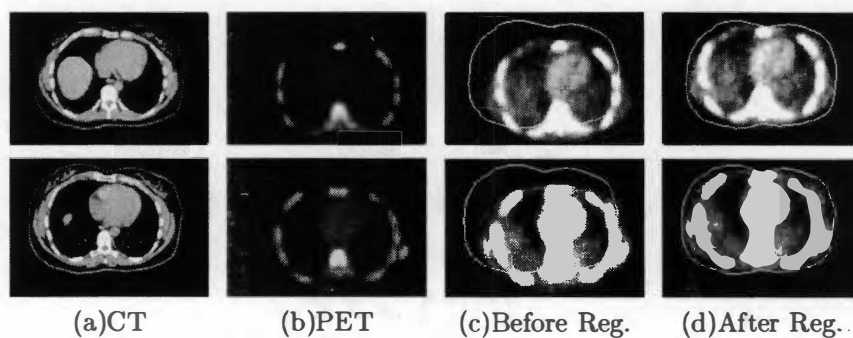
Two pairs of CT/PET images from the second dataset and registration result by the combined mutual information
